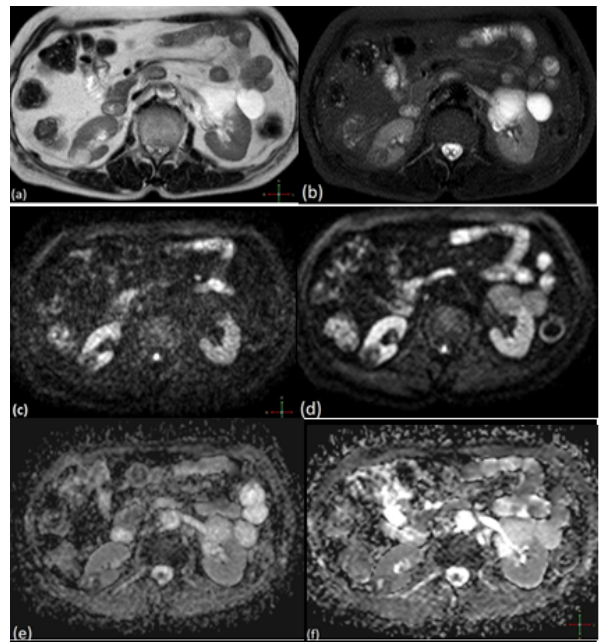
a-e) Angiomyolipoma of the right kidney in a 78-year-old female patient, which is hyperintense on T2-w image (a); losing signal in the fat suppressed sequence (b); showing locally restricted diffusion on DWI (c-e); with ADC values measured as 1.21×10^{-3} mm²/s at $b=1000$ (d) and 1.67×10^{-3} mm²/s at $b=500$ (e)
